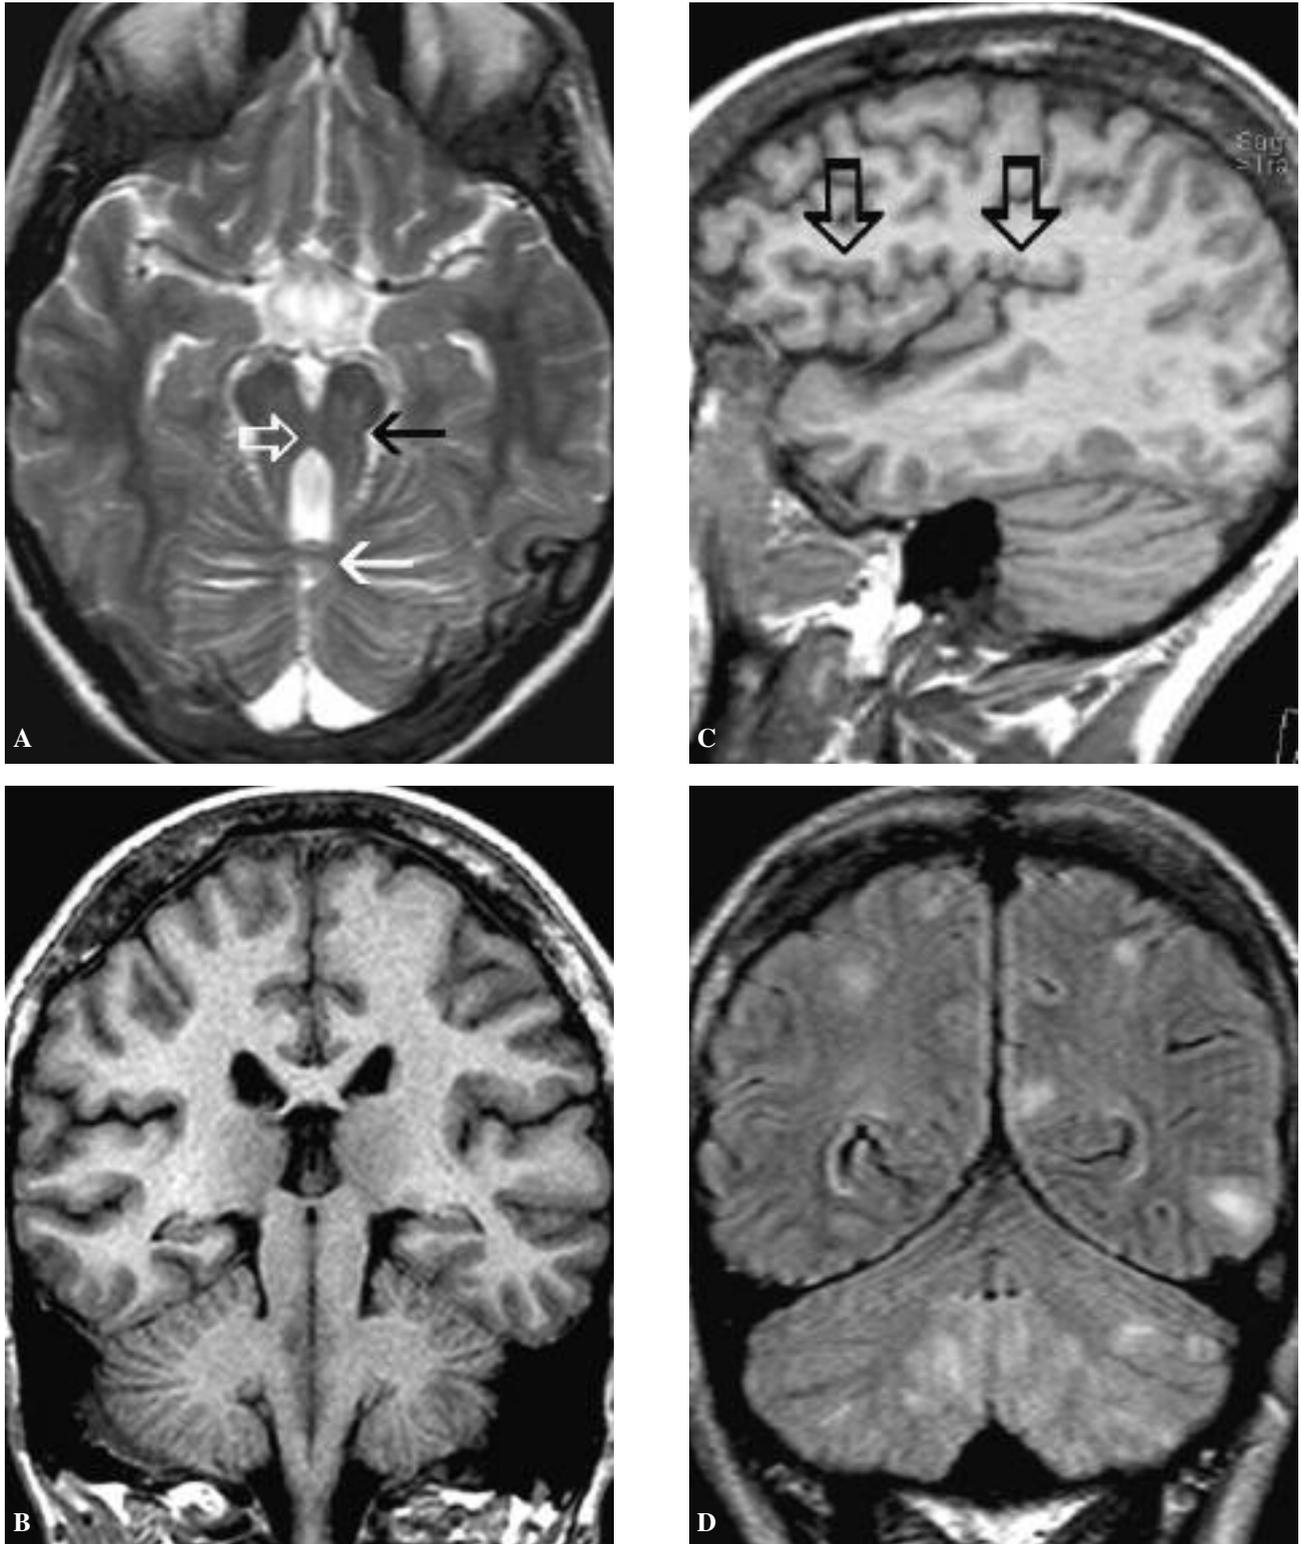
A. Axial T2 weighted magnetic resonance image (MRI) shows typical deep interpeduncular fossa and “molar tooth” appearances of the brainstem (arrow), high signal intensity in decussation of the superior cerebellar peduncles (open arrow). Small cerebellar vermian remnant (white arrow) is also seen. B. Coronal T1 weighted inversion recovery MRI shows deep cortical sulci and fissures. C. Sagittal T1 weighted inversion recovery MRI shows polymicrogyric cortex in right frontal lobe-perisylvian region (open arrows). D. Coronal FLAIR T2 weighted MRI shows multiple hyperintense areas in patchy distribution of the cerebral cortical / sub-cortical regions and cerebellum.
